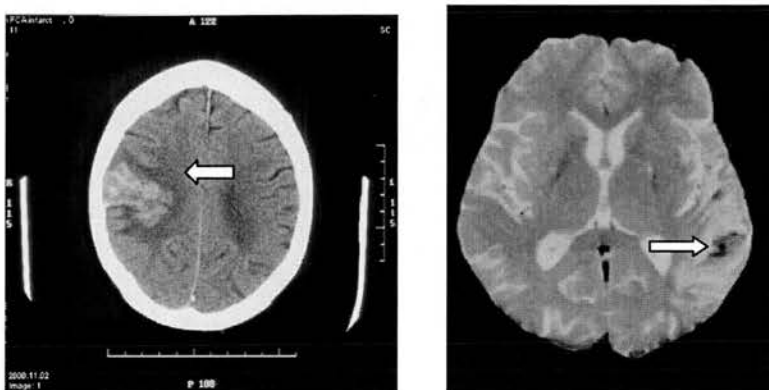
Haemorrhagic transformation. Left: CT showing a heterogeneous area of hyperdensity surrounded by hypodense oedema (arrow). Right: MRI gradient echo sequence, showing irregular area of hypointensity surrounded by relative hyperintensity (arrow)
